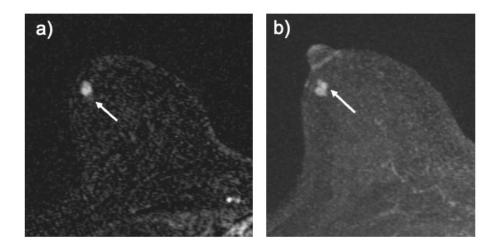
Representative case of MRI-detected cancer. 38 y.o., a lesion was detected on the second MRI screening round, 8 mm mass (white arrow), IDC, Luminal A-like subtype, Ki-67 <10%, historical grade 1. a) Axial MPR image, b) MIP image of an early phase of DCE MRI (1.5 T MRI). DCE dynamic contrast-enhanced, MPR multi-planar reconstruction, MIP minimum intensity projection, IDC invasive ductal carcinoma.
